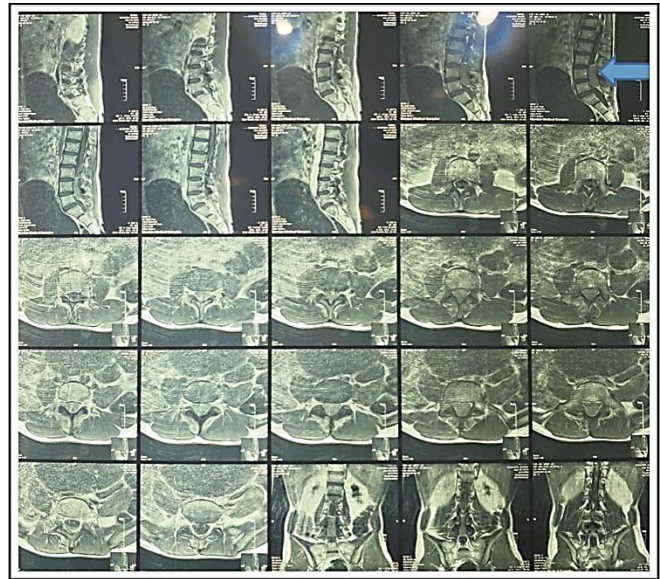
MRI of the Patient (after informed consent) showing the spinal tumor.
